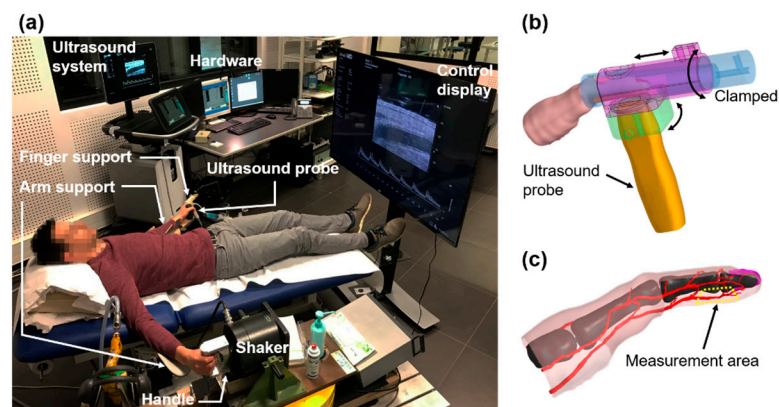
Experimental setup: (a) overall view; (b) positioning support of the ultrasound probe; (c) measurement area corresponding to the proper volar digital artery of the left index finger.
